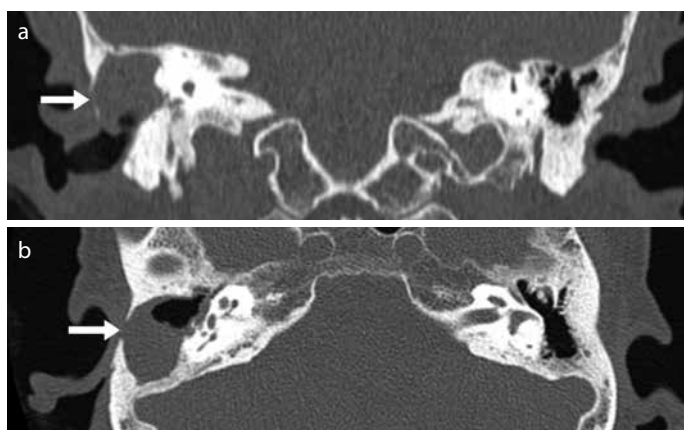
a, b. High-resolution computed tomography axial (a) and coronal (b) images showing a defect in the lateral wall of the mastoid bone (arrow). The middle ear cavity was filled with soft tissue density, and ossicles were not observed.
